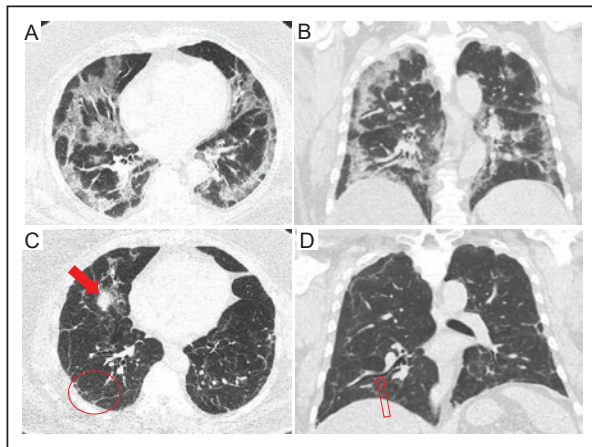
Chest CT of a 59-year-old male diagnosed with Long COVID. A: coronal and B: axial baseline images showing multifocal areas of ground-glass opacity with predominantly peripheral distribution (solid arrows). C: coronal and D: axial images of follow-up, obtained 18 months after the initial infection, show atelectasis (solid arrow), peripheral septal thickening (circle), and residual cylindrical bronchiectasis (open arrow).
